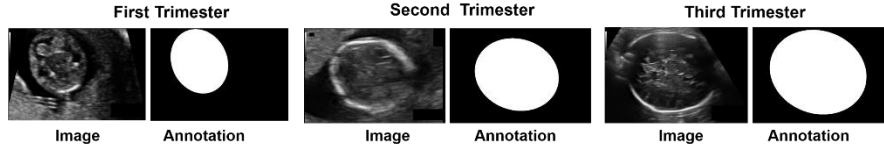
Trimester-wise fetal ultrasound images with ground-truth annotations.
